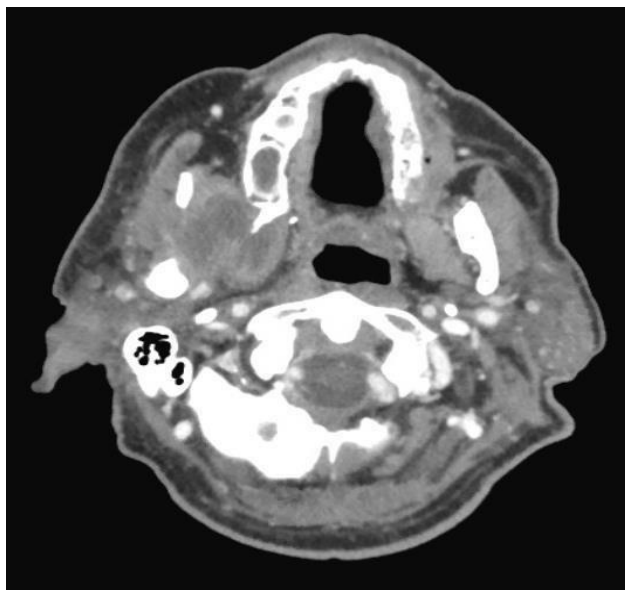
A) Axial CT demonstrates enhancement within the right pterygoid musculature
